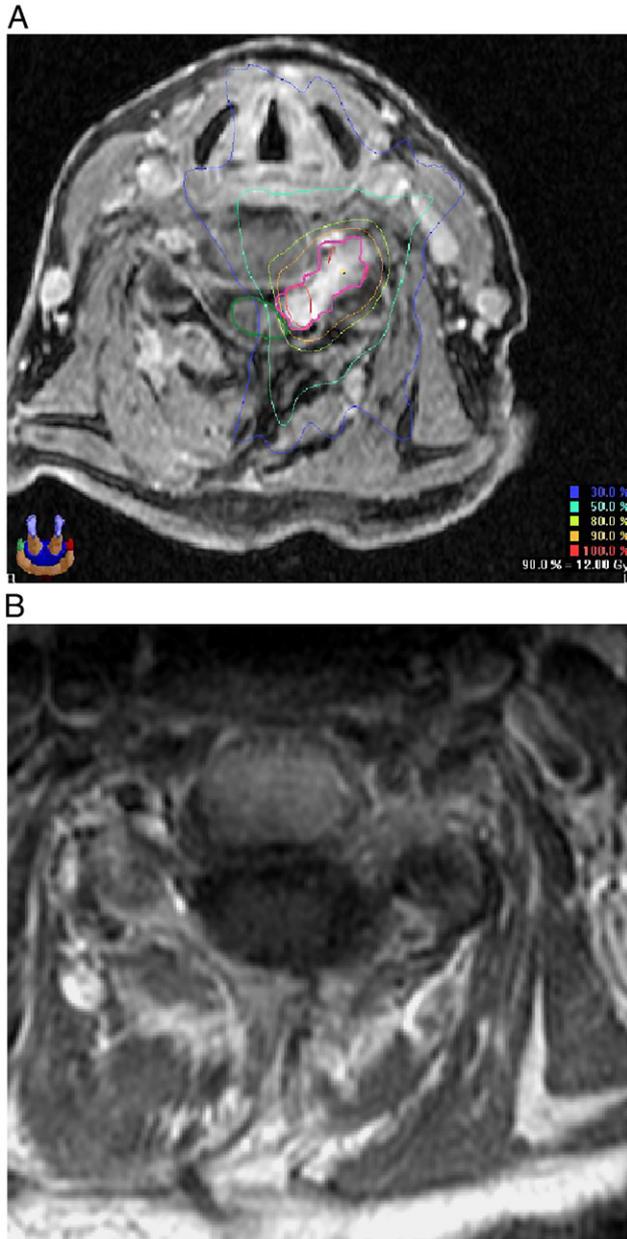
A: Axial contrast-enhanced MRI demonstrates a 2 cm/3.14 mL C6 SCH. Isodose lines displayed: 100% (thin red), 90% (yellow), 80% (light green), 50% (teal), 30% (blue). The target (thick pink) received 12 Gy prescribed at the 90% isodose. B: Axial contrast-enhanced MRI 18 months after radiosurgery.
